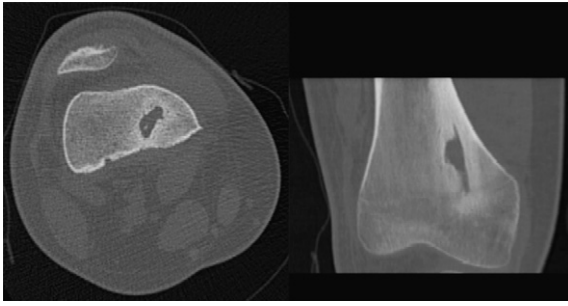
CT image from December 2010 showing a well-defined radio-lucent lesion in the distal right femur with a dense sclerotic margin.
